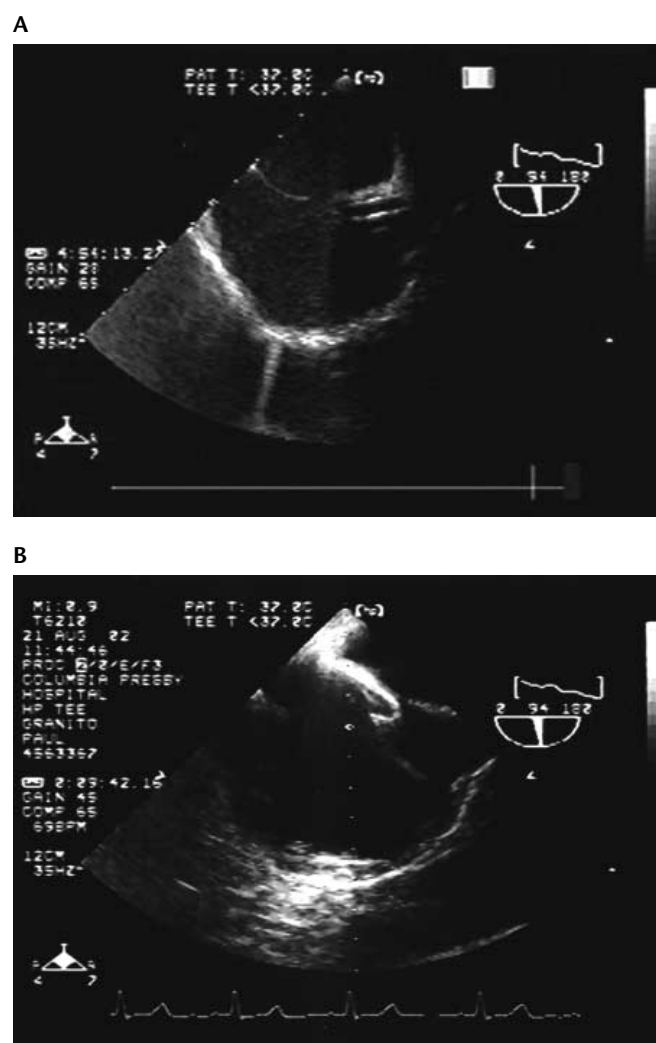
A, Ultrasound image of the superior vena cava cannula. B, Ultrasound image of a bicaval view depicting the inferior vena cava containing a J guidewire. Both views are helpful in correctly placing cardiopulmonary bypass venous cannulas.
